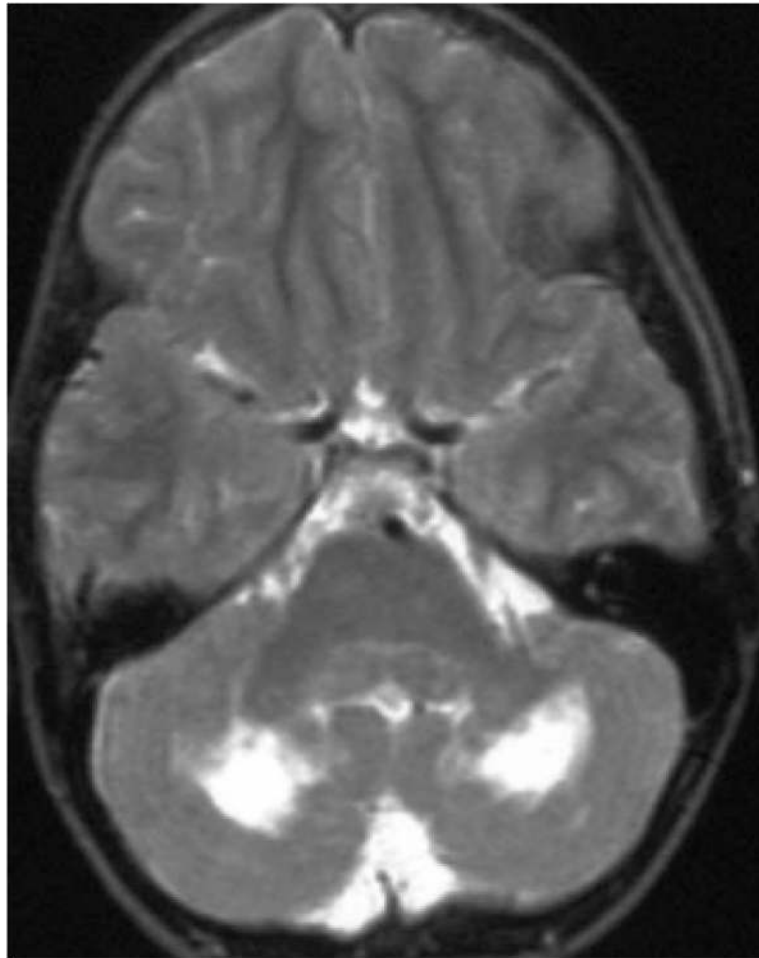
T2-weighted axial MRI in a patient with Langerhans cell histiocytosis, showing hyperintense signal abnormality in the white matter of the cerebellum.¹⁸²
